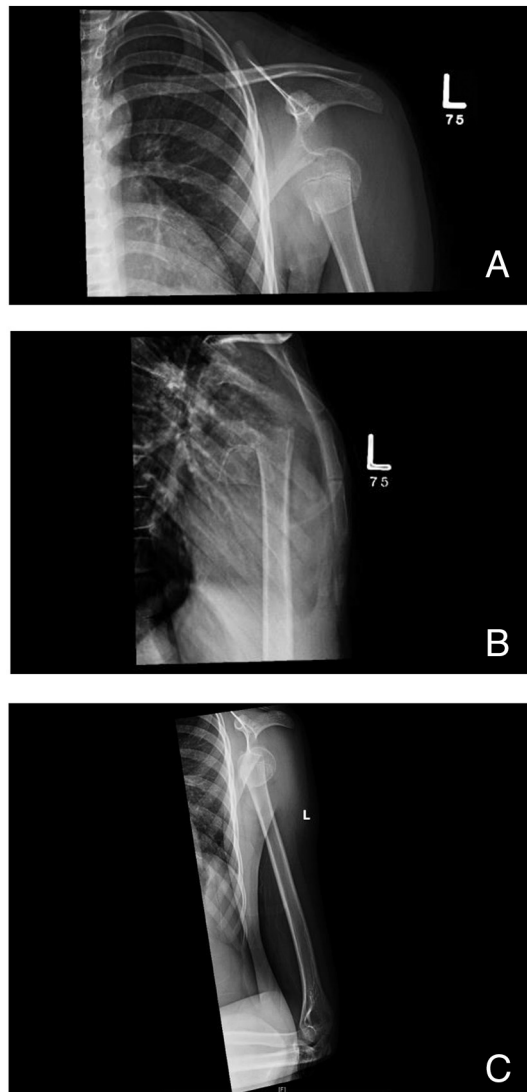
A: AP (anterioposterior), B: Lateral shoulder and C: Lateral humerus X-rays demonstrating the humeral surgical neck fracture with a posterior shoulder dislocation.
